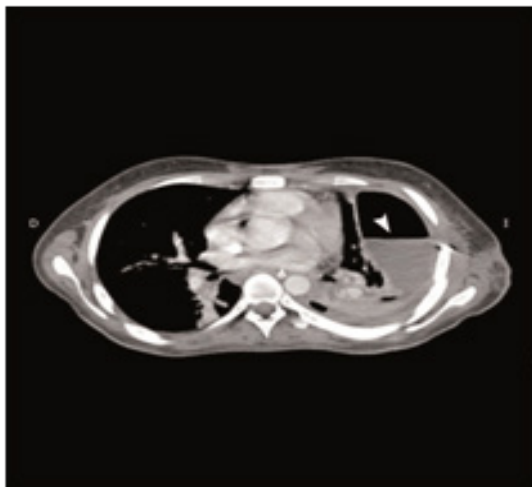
Contrast thoracic CT scan showing a left pleural effusion (white arrow).
